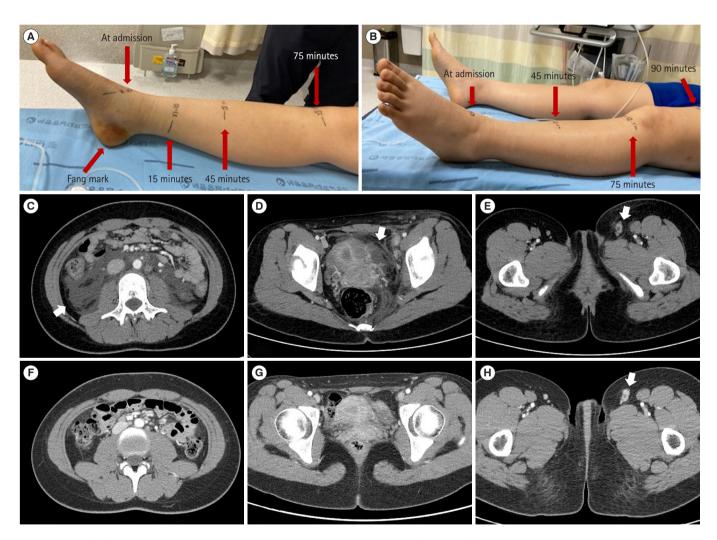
Case 1. (A, B) Progression of left leg swelling after admission to the local hospital (red arrows). (A) At admission 10 minutes after the snakebite. At 75 minutes after the snakebite, the swelling progressed to the knee. (B) At 90 minutes after the snakebite, the swelling progressed to the proximal femur. (C–E) Abdominopelvic computed tomography was performed on the 2nd day after the snakebite. (C) Markedly progressed retroperitoneal fluid was identified (white arrow). (D) Ascites were observed in the pelvic cavity (white arrow). (E) Lymphadenopathy was identified in the left proximal femoral area (white arrow). Abdominopelvic computed tomography was performed on the 7th day after the snakebite and showed (F) markedly improved retroperitoneal fluid volume, (G) markedly improved ascites in the pelvic cavity, and (H) persistent lymphadenopathy at the proximal femoral area (white arrow).
